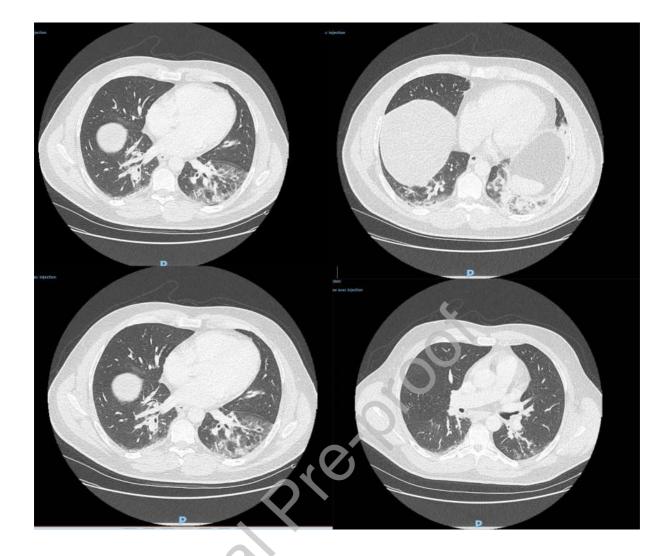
Chest computed tomography performed at baseline. Bilateral ground glass opacities appear in inferior lobes
